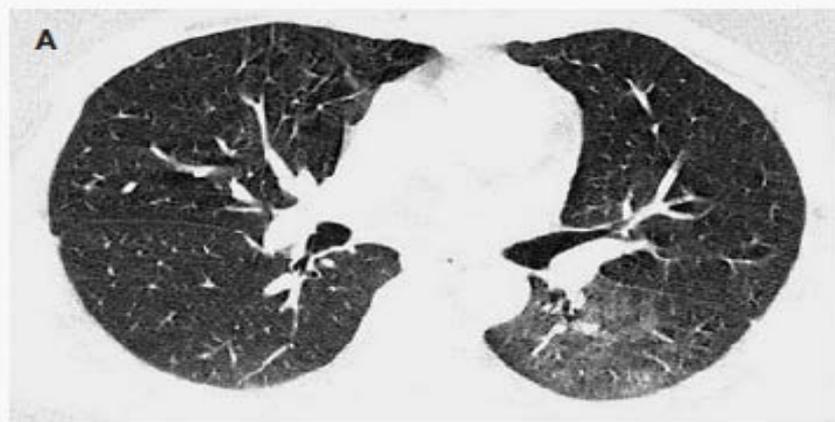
High-Resolution Computed Tomographic Scan of the Chest Showing Ground-Glass Opacity at the Apical Segment (Panel A) and Superior Aspect of the Posterior Segment (Panel B) of the Left Lower Lobe.
